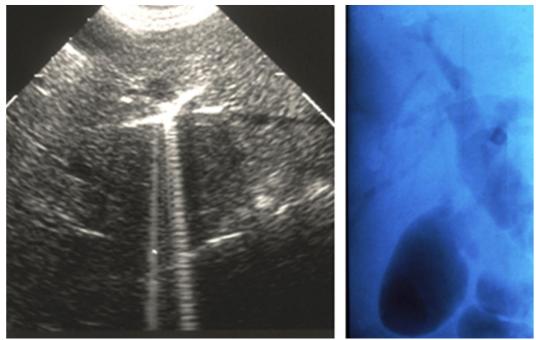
a, b Aerobilia and aerocystia in high-impedance echo typical for gases, as well as reverberations between bile duct walls and the gas, aerocystia after extensive EPT; SCS right (a); note the differences in the pictures, which are triggered by the gas in x-ray and ultrasound technique.
